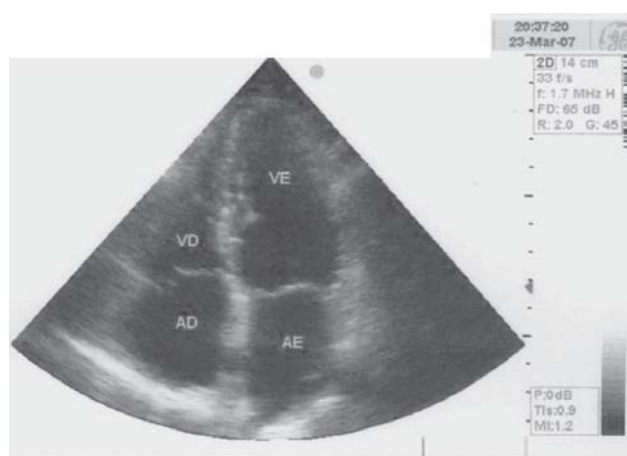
Control echocardiographic study performed 93 months after the tumor resection. Absence of suggestive signs of recurrence
